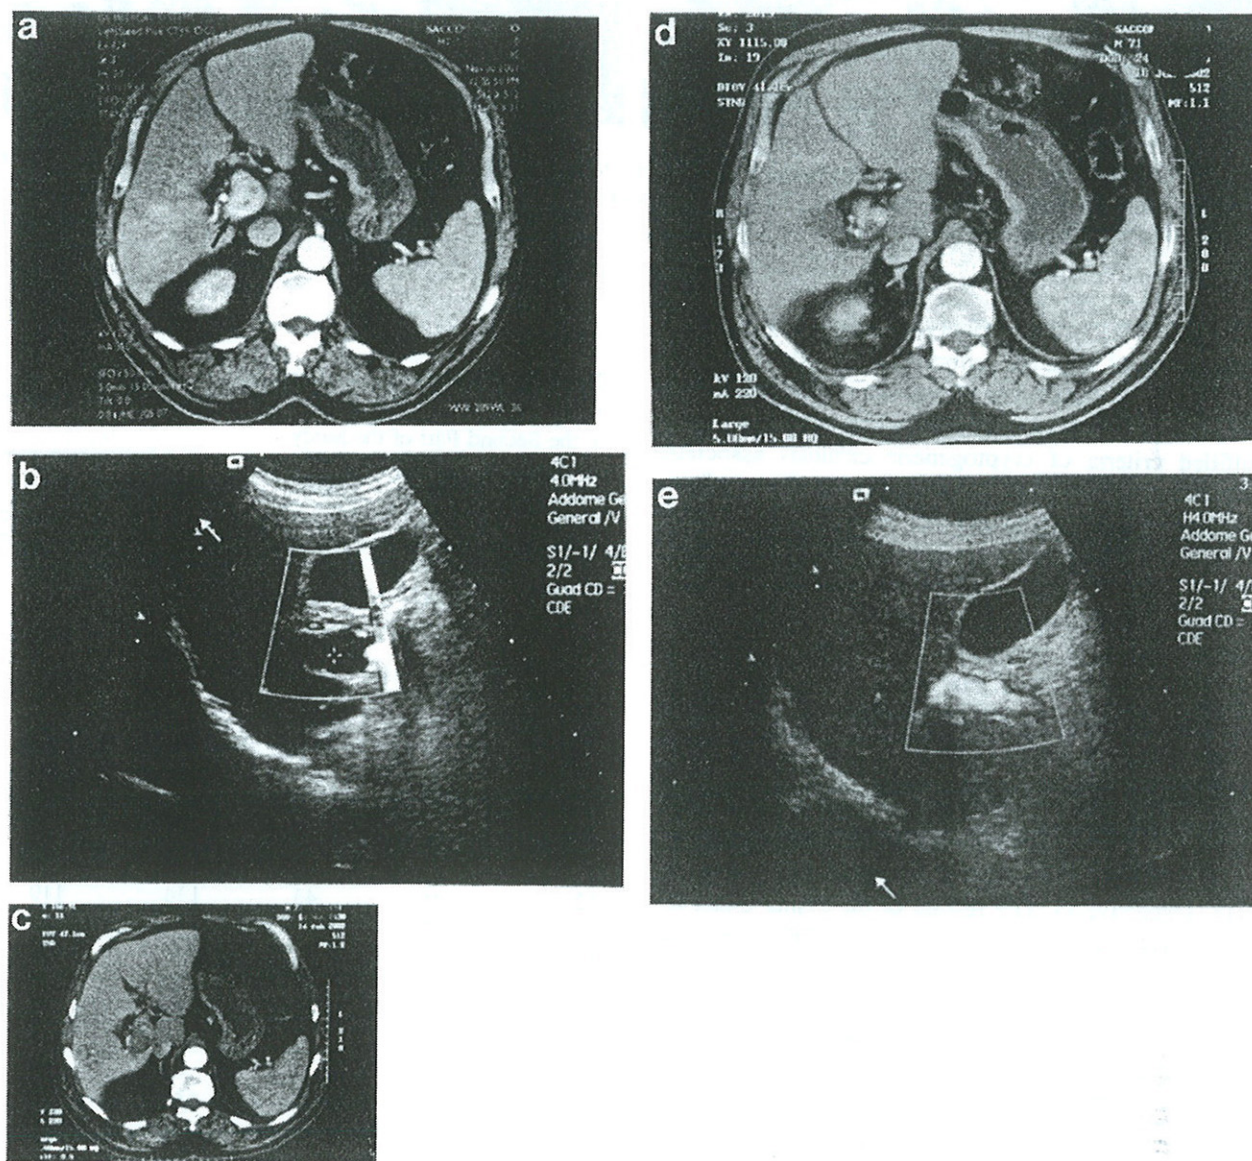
(a) Spiral CT scan during the arterial phase performed prior to treatment shows an advanced HCC of the right lobe. Scattered neoplastic hypervascularized areas are present in segment 7, and a hypervascularized thrombus (arrow) occupies the right portal branch and reaches the main trunk. (b) Power Doppler examination confirms the thrombosis (asterisk) inside the main portal vein. (c) Spiral CT scan during the arterial phase performed 3 months after treatment shows the disappearance of the neoplastic areas and evident reduction of the arterial supply inside the thrombus. (d) Spiral CT performed 6 months after treatment shows the shrinkage of the portal thrombus and confirms the disappearance of the HCC in the right lobe. The same pattern was confirmed 21 months after treatment. (e) Power Doppler examination confirms the shrinkage of the thrombosis and the patency of the main portal vein.
